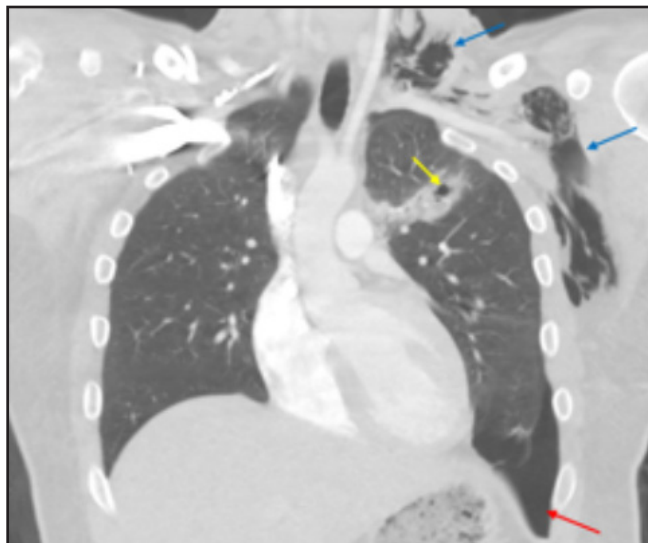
Pulmonary laceration and associated hemorrhage. Axial and coronal contrast-enhanced CT images in a patient with a gunshot wound demonstrating a pulmonary laceration and hemorrhage (yellow arrow) with a pneumothorax (red arrow). Left supraclavicular and lateral chest wall subcutaneous emphysema (blue arrows) is also present.
